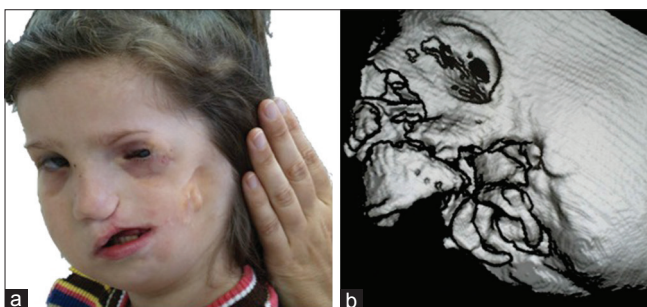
Pruzansky-Kaban Type III. The mandibular ramus, condyle, and temporomandibular joint are absent. The lateral pterygoid muscle and temporalis muscle, if present, are not attached to the mandibular remnant. (a) Three-fourths profile view of an affected girl; (b) three-dimensional (3D) reconstruction of a multi-slice computed tomography (CT) scan of the same girl as in a, showing the absence of the vertical ramus. The patient also had a unilateral cleft lip, alveolus, and palate
